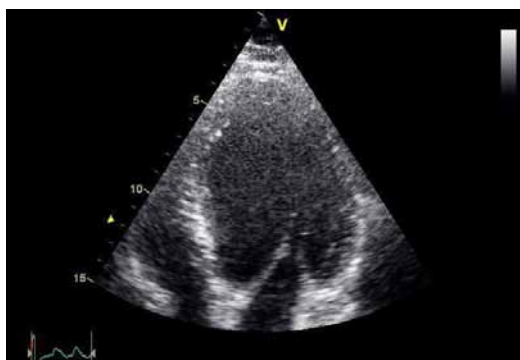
Echocardiogram (apical view) showing dilated LV.
